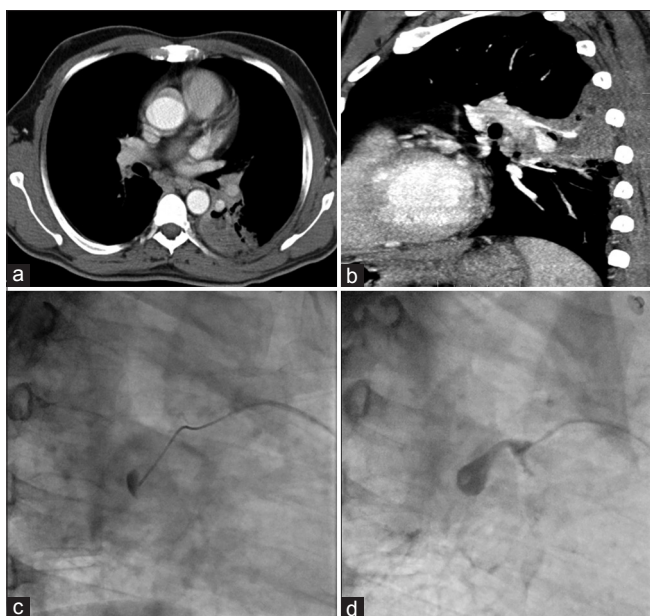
Axial and sagittal reformatted sections of contrast-enhanced computed tomography chest (a and b) in mediastinal windows showing subsegmental area of consolidation in superior segment of the left lower lobe with two pulmonary artery pseudoaneurysms noted arising from superior segmental branch of the left pulmonary artery, larger measuring 11 mm x 9 mm. Oblique projection of catheter pulmonary angiography (c) selective injection of contrast after cannulation of segmental branch showing opacification of pseudoaneurysm. Oblique projection fluoroscopic image (d) showing glue injection in pseudoaneurysm
